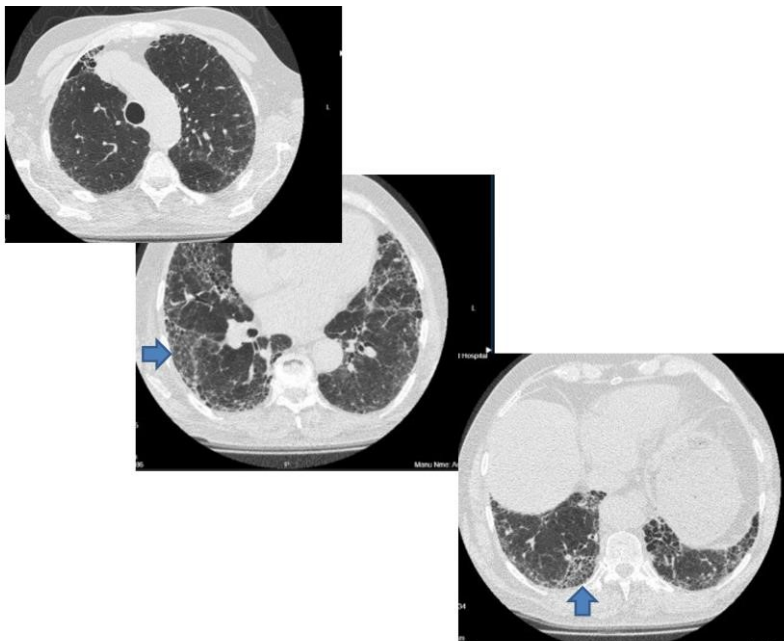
Patient with diagnosed IPF with HRCT pattern consistent with UIP. Reticulation with honeycombing  Picture shown with permission from Bristol ILD Service MDT.
